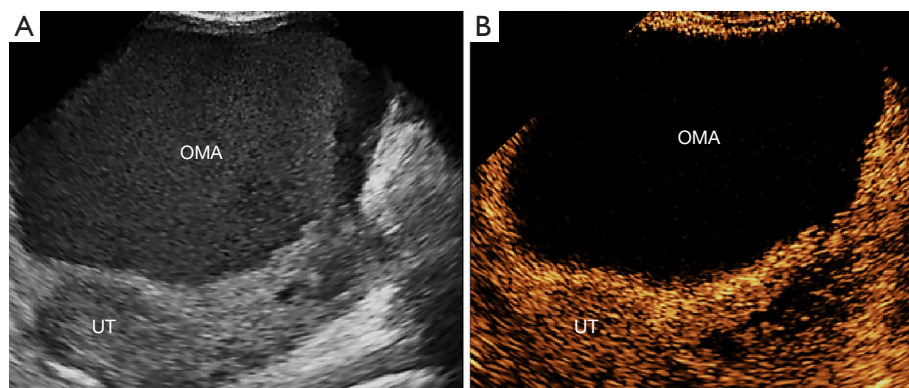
Preoperative evaluation of OMA. (A) Ultrasonography showed a smooth-wall cyst with no bulges, intracapsular separation, and blood flow signals. (B) Contrast-enhanced ultrasonography showed safe pathways for puncture. OMA, ovarian endometrioma; UT, uterus.
